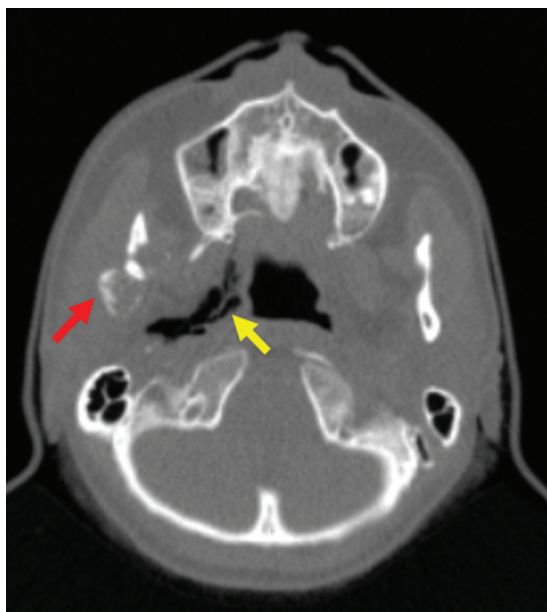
Osteosarcoma of the right mandibular condyle (red arrow). The presence of air around the right parapharyngeal space in the maxilla level (indicated by yellow arrows) was confirmed by computed tomography.
